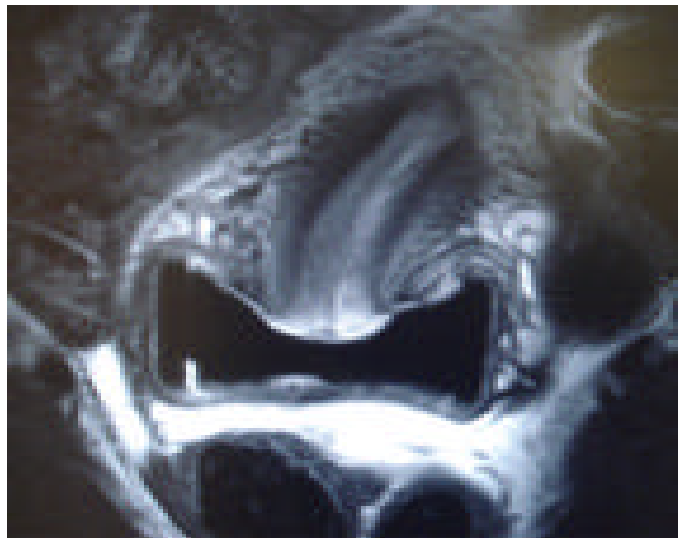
Endovaginal coil MRI of cervix (A: Cross section, B: Longitudinal section)
